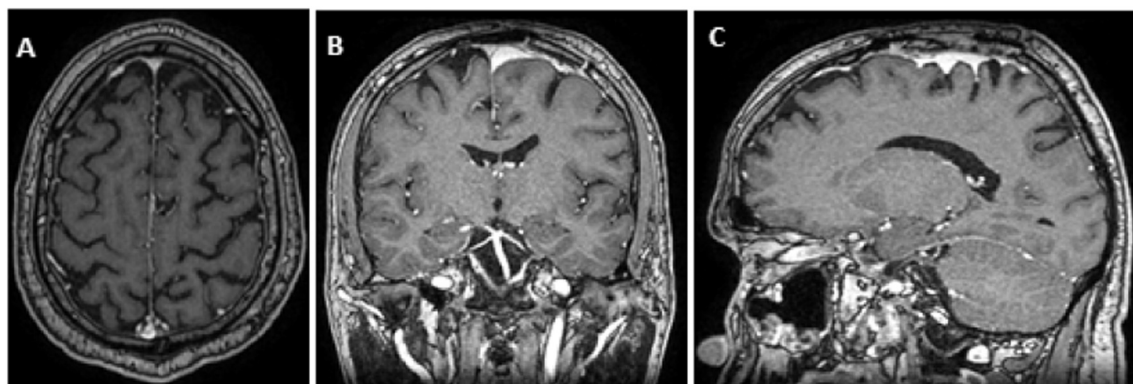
Postoperative MRI in axial T1 (A), coronal (B) and sagittal (C) presenting resolution of hypertensive cyst and reexpansion of cerebral cortex.
